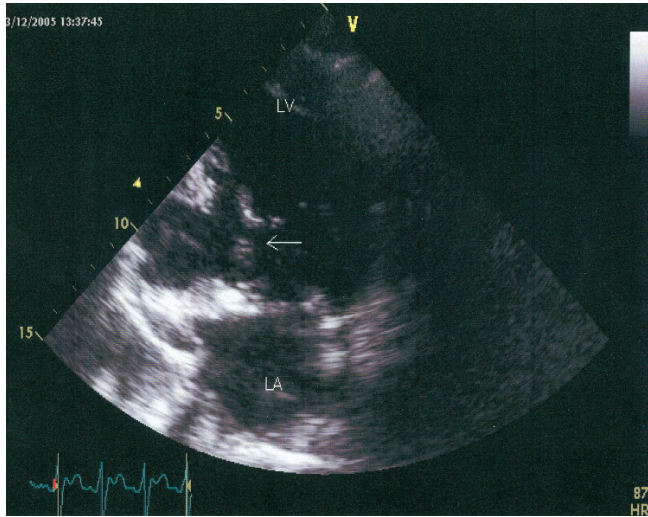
Discontinuity of myocardium (arrow) in pseudoaneurysm on the inferior wall of the left ventricle demonstrated by color flow Doppler transthoracic echocardiography in apical two chamber view.
